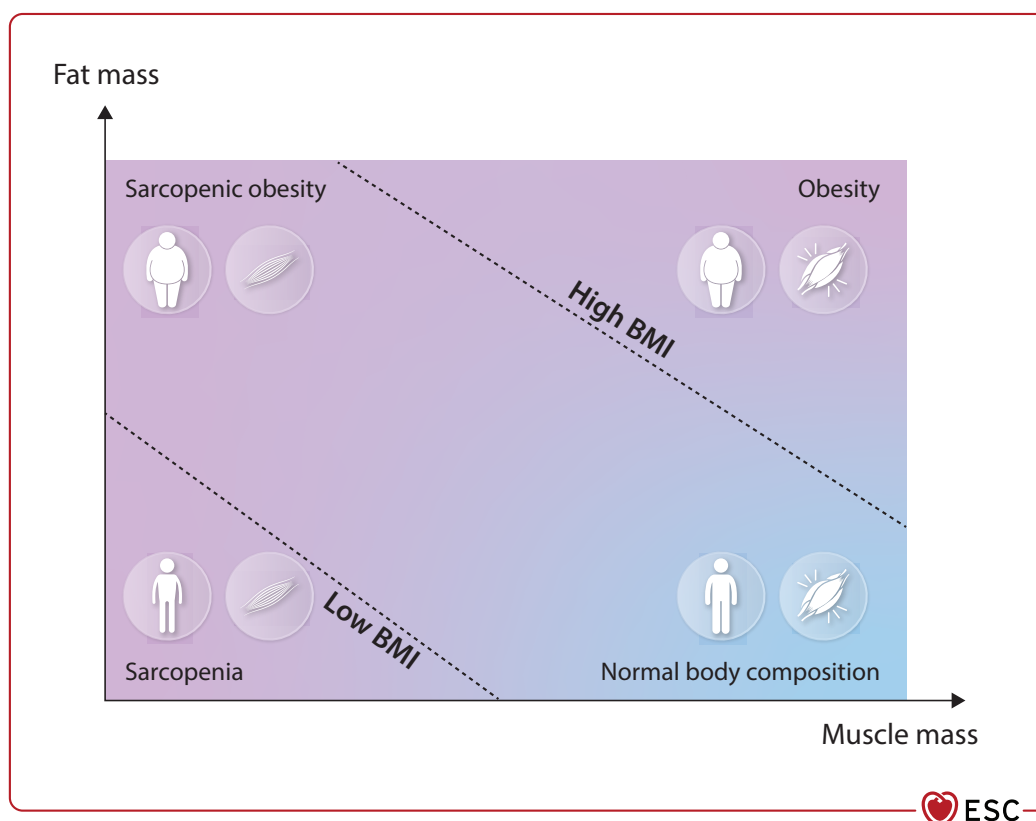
Matrix of body composition abnormalities and limitations of body mass index. BMI, body mass index. Pink areas indicate that body composition abnormalities (obesity, sarcopenic obesity, and sarcopenia) may occur irrespective of BMI. The diagnosis of sarcopenia and sarcopenic obesity is based on body composition measurements (e.g. appendicular lean mass by dual X-ray absorptiometry) and requires assessment of muscle function (e.g. muscle strength) (see [Supplementary data online, Table S8](#)).
